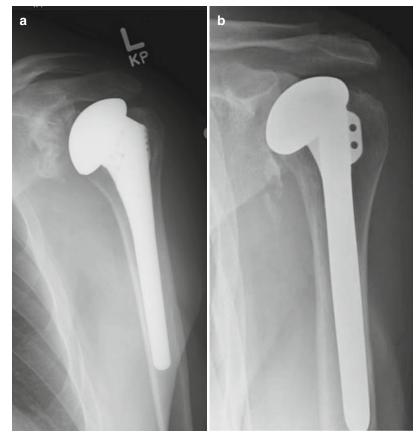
These anteroposterior radiographs demonstrate two components, (a) one with variable offset and inclination and (b) one with fixed offset and inclination.
